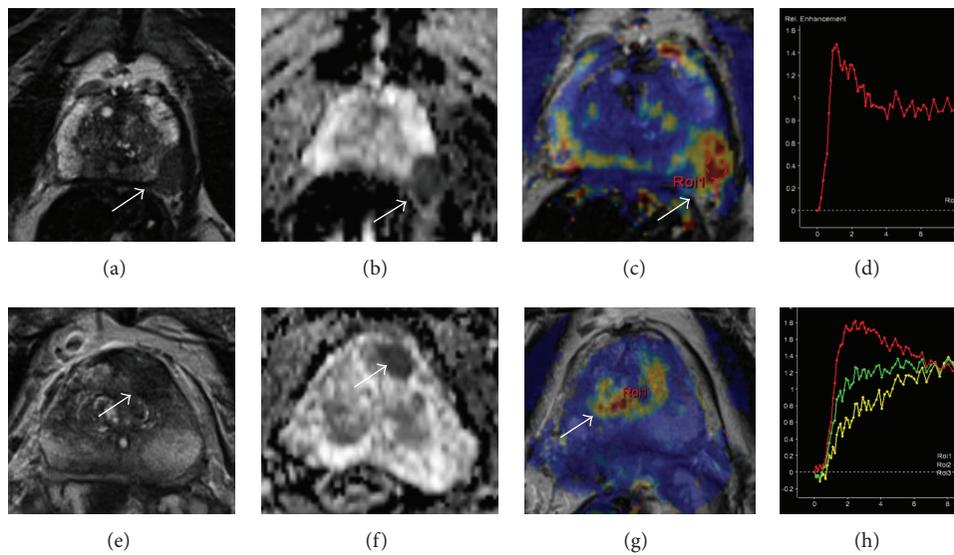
Suspicious lesions (arrows) on mpMRI with different PI-RADS sum-scores. Gleason 8 carcinoma: 5 points on T2W for hypointensity and bulging (a), 5 points on DWI for focal very low ADC (b), and 5 points on DCE-MRI for washout curve in a focal lesion (c, d) = sum-score of 15 points. Gleason 7 (3 + 4) carcinoma with 4 points on T2W for focal hypointensity (e), 5 points on DWI for focal very low ADC (f), and 3 points on DCE-MRI for symmetrical washout curve without focal lesion (g, h) = sum-score of 12 points.
